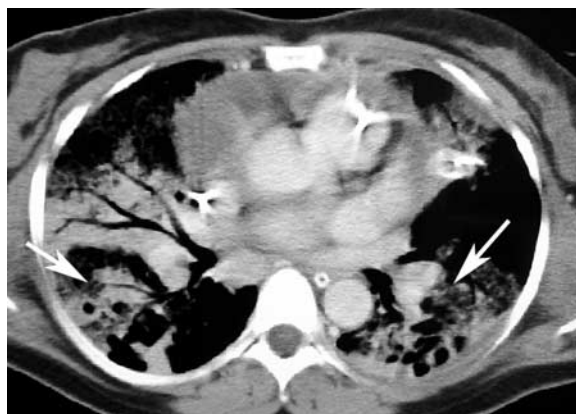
Pneumonia due to *Pseudomonas aeruginosa*. Contrast-enhanced CT of a 68-year-old man shows bilateral multifocal focal areas of consolidation and cavitation consistent with abscess formation (arrows). Note a middle lobe consolidation with visible air bronchogram.
